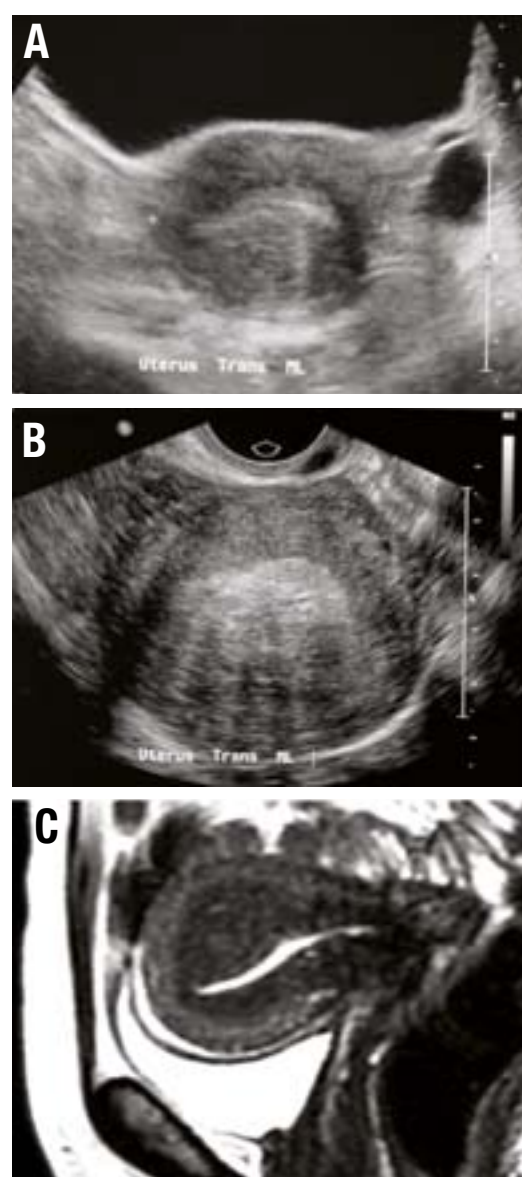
A: Transabdominal sonography showing asymmetrical myometrial thickness. B: Transvaginal sonography was incorrectly reported as demonstrating a posterior wall fibroid. In fact, an inhomogenous posterior wall echo and “Venetian blinds” appearance are highly suggestive of adenomyosis. C: MRI demonstrated typical appearance of posterior wall focal adenomyosis.
